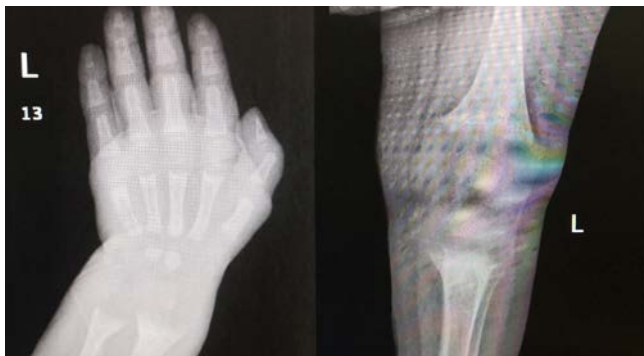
X-rays of wrist and knee showing cupping, flaring, and flaying.
